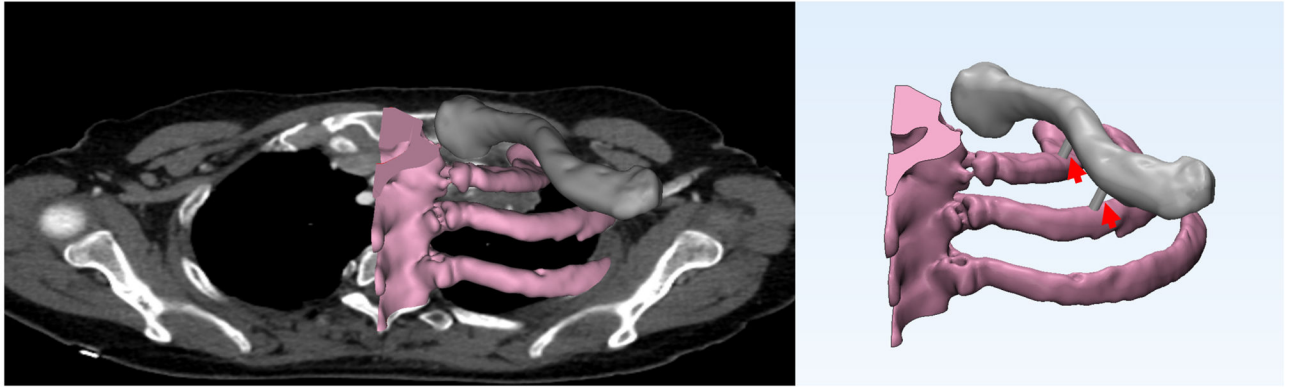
Addition of non-anatomic features to STL models of the clavicle and ribs segmented from a CT for inclusion in a superior sulcus tumor model
